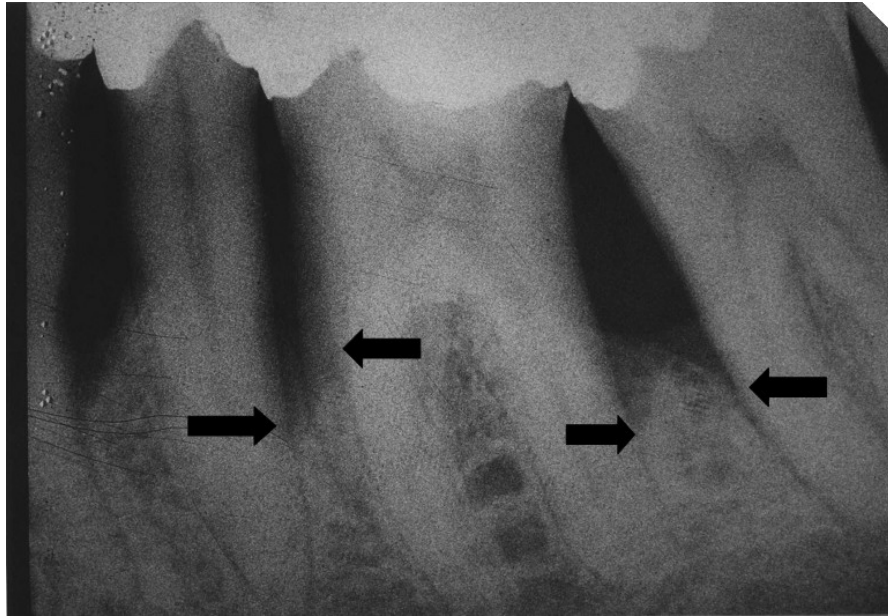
Pretreatment radiograph showing bone loss and infrabony defects between several teeth.
